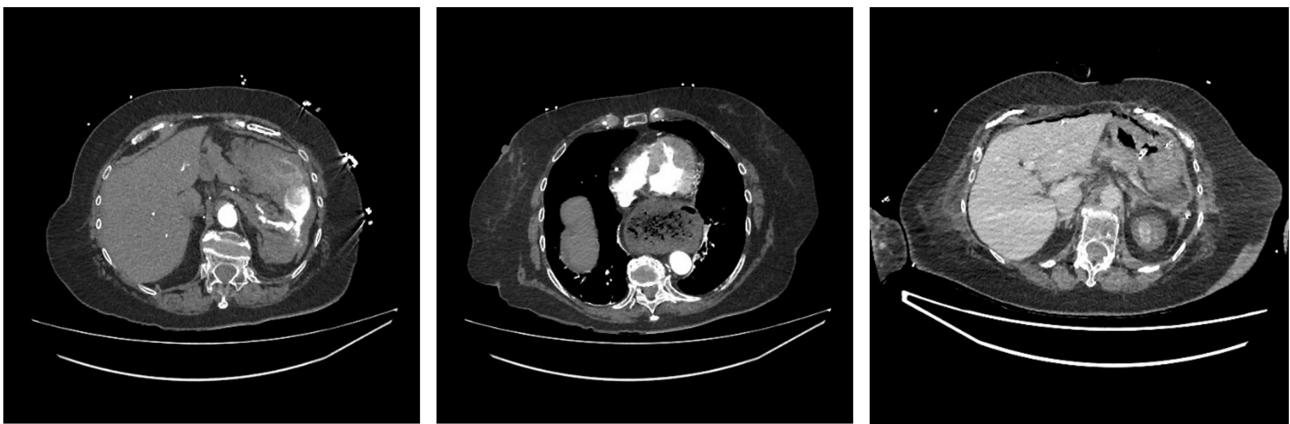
Axial computed tomography image showing splenic artery aneurysm.
